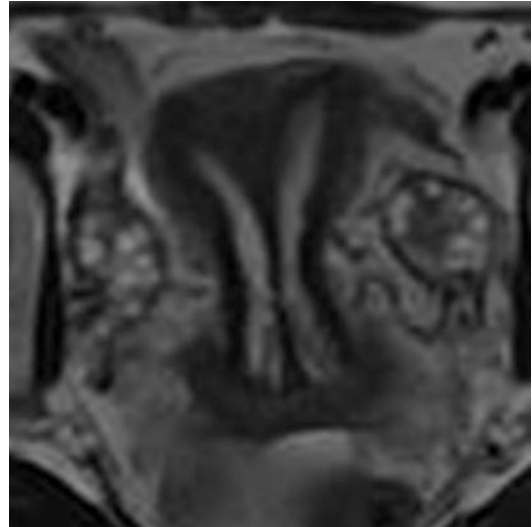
MRI of complete septate uterus. Note the uterine fundus is convex and unified with two separate endometrial cavities. This is the same patient with HSG in Fig. 7.5 (Image provided by Samantha M. Pfeifer MD)
